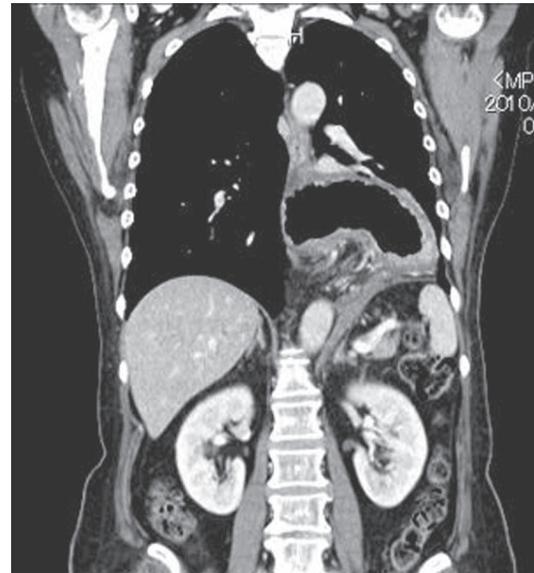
Computed tomography confirmed herniation of most of the stomach into the mediastinum.
